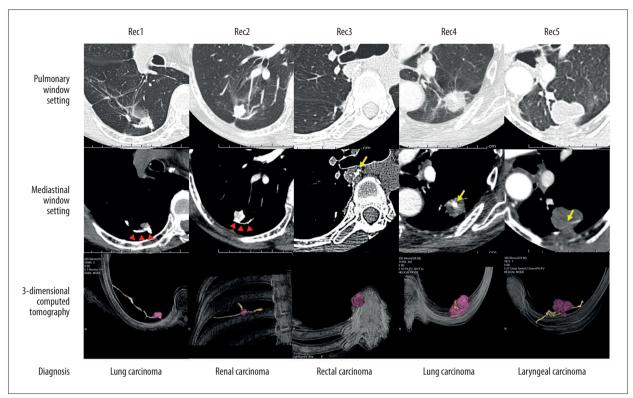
Five cases of stump recurrence in our institution (Rec1–5). All cases underwent wedge resection. Staple lines in Rec1 and Rec2 are along the edge of tumor (red arrowheads). Staple lines in Rec 3–5 are surrounded by tumor (yellow arrows). All lesions are irregular in shape, as inaccurate circles. 3-dimensional computed tomography reveals that all cases of recurrence (purple shadow) are shaped like almost sphere and grow concentrically or radially from the staple line (line of khaki).
